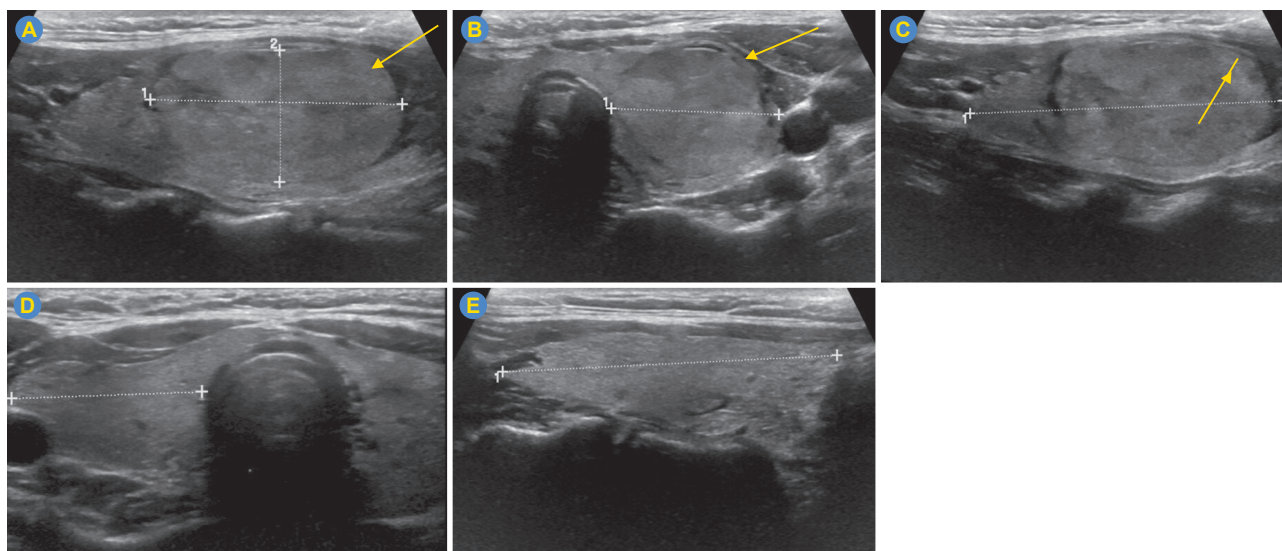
B-mode ultrasound of the thyroid shows an isoechoic well-defined solid nodule in the left thyroid lobe (arrow), with a fine-needle aspiration result of papillary carcinoma, measuring 3 cm (A). The right and the left lobe diameters are measured in the paramedian transverse and longitudinal planes to determine lobe volume. The total thyroid gland volume was estimated at 12 cc, under 15 cc (B, C, D), making the case suitable for TOEVTA approach.
